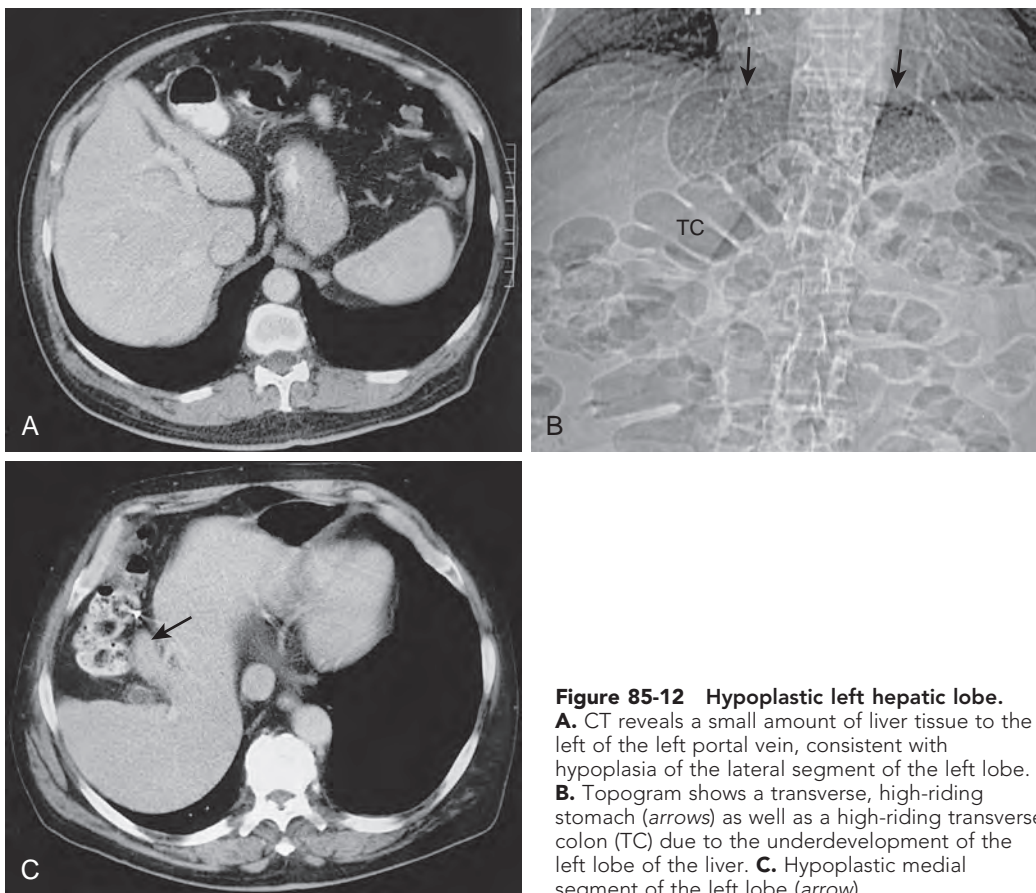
Hypoplastic left hepatic lobe. A. CT reveals a small amount of liver tissue to the left of the left portal vein, consistent with hypoplasia of the lateral segment of the left lobe. B. Topogram shows a transverse, high-riding stomach (arrows) as well as a high-riding transverse colon (TC) due to the underdevelopment of the left lobe of the liver. C. Hypoplastic medial segment of the left lobe (arrow).
